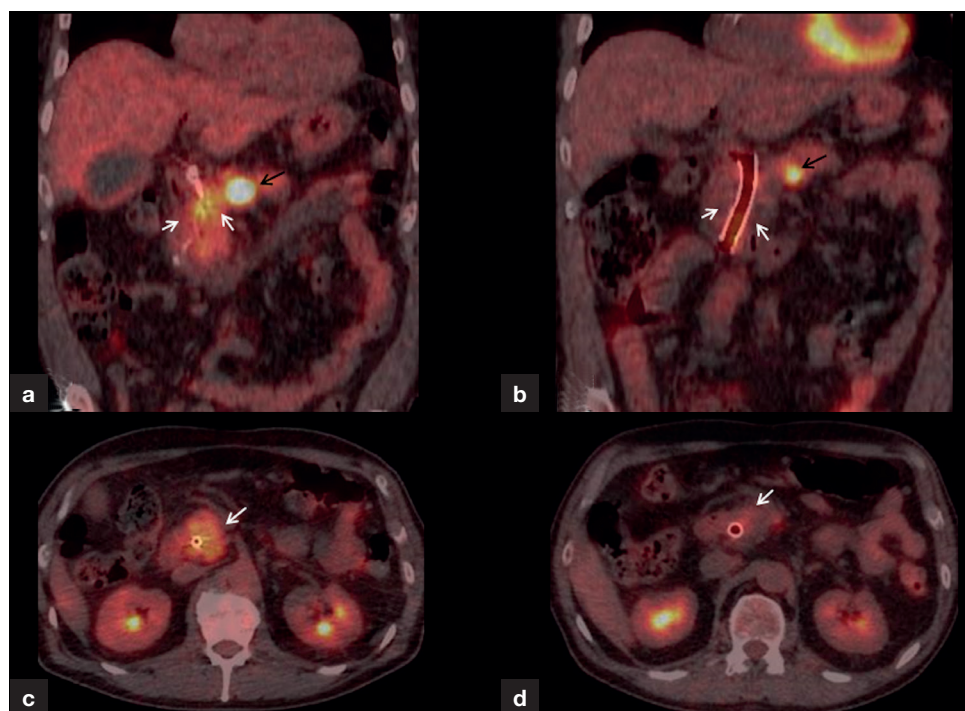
Combined positron emission tomography-computed tomography of pancreatic adenocarcinoma pre- and post-neoadjuvant chemotherapy. a. Pre-treatment coronal positron emission tomography-computed tomography image shows a metabolically active tumour in the head of pancreas (white arrows). There is also a hypermetabolic peripancreatic node (black arrow). b. Post-treatment scan shows reduced activity and size of the primary and the node. Axial images of (c) pre- and (d) post-treatment positron emission tomography-computed tomography demonstrates reduced activity and size of the head of pancreas tumour (white arrows).
